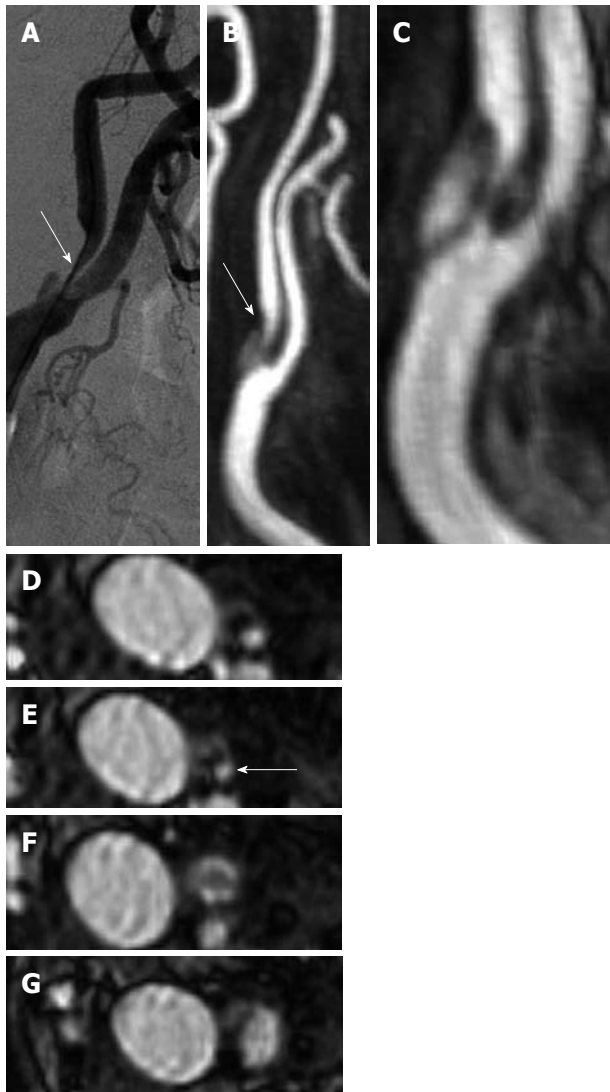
Digital Subtraction Angiography (A), CTA (B) and MRA (C-F) of the right carotid artery of a 74-year-old patient with right transitory ischemic attack. The blue arrows indicate the point of maximum stenosis degree.
